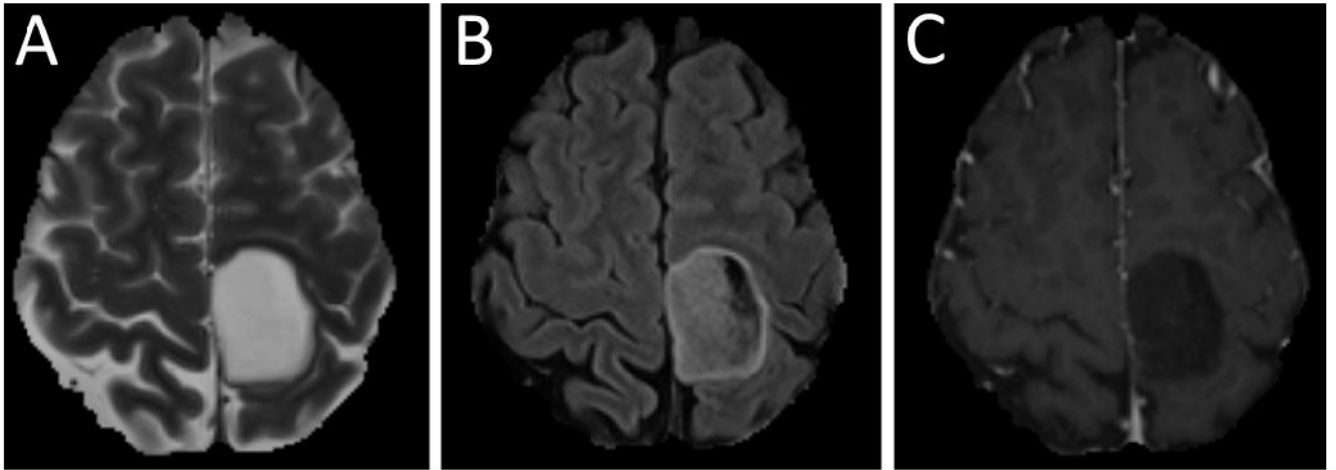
Complete T2-FLAIR mismatch sign in a 25-year-old patient with a left frontoparietal IDH-mutant WHO grade 4 astrocytoma that shows homogeneous T2-hyperintense signal (A), FLAIR suppression except for a thin hyperintense rim (B), and no enhancement on postcontrast T1-weighted images (C).
